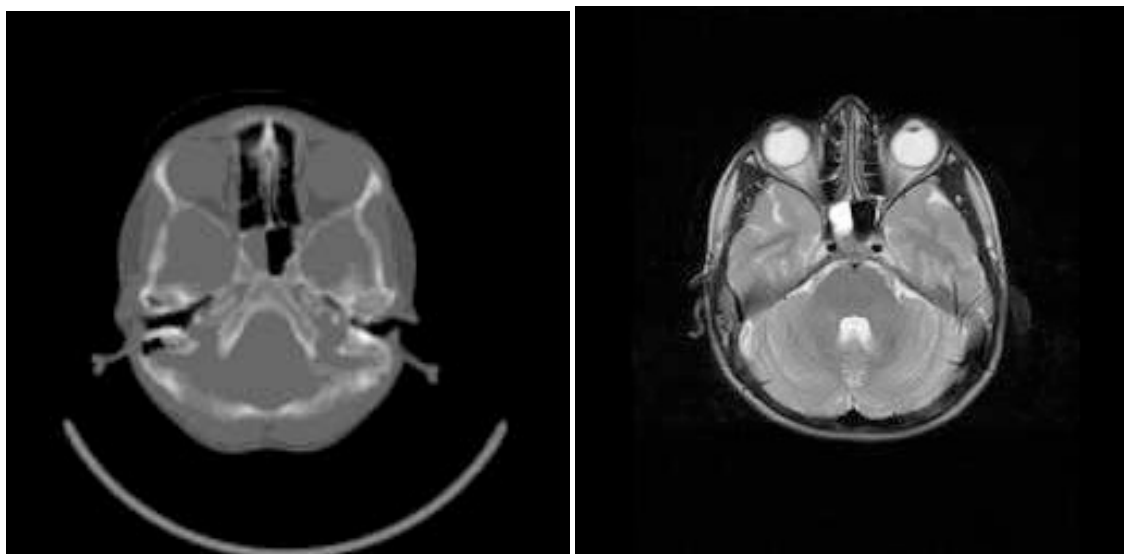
CT and MR scan showing: Right isolated sphenoid sinus opacification
